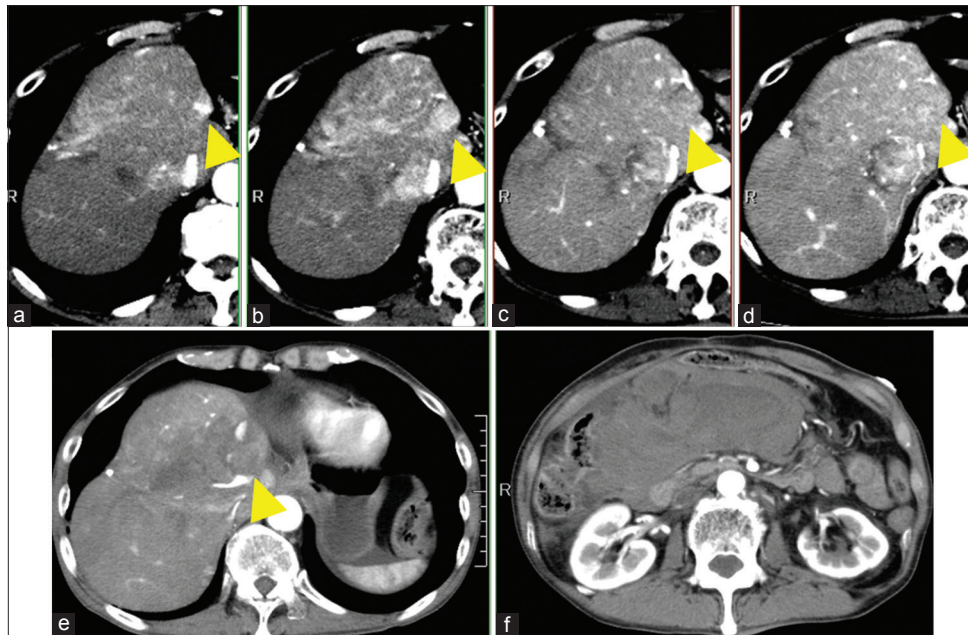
Enhanced CT showed HCC in the liver S4. (a) 15 months, (b) 8 months, (c) 4 months, (d) 1 month before the tumor rupture. The ruptured tumor was indicated by arrows. Sorafenib was started at 14 months before the rupture. The vascularity of the tumor was gradually decreased. The size of tumor was within stable disease. (e) Enhanced CT showed HCC rupture in the liver S4. The extravasation from tumor (arrow), (f) intraperitoneal hematoma. HCC: Hepatocellular carcinoma; CT: Computed tomography.
